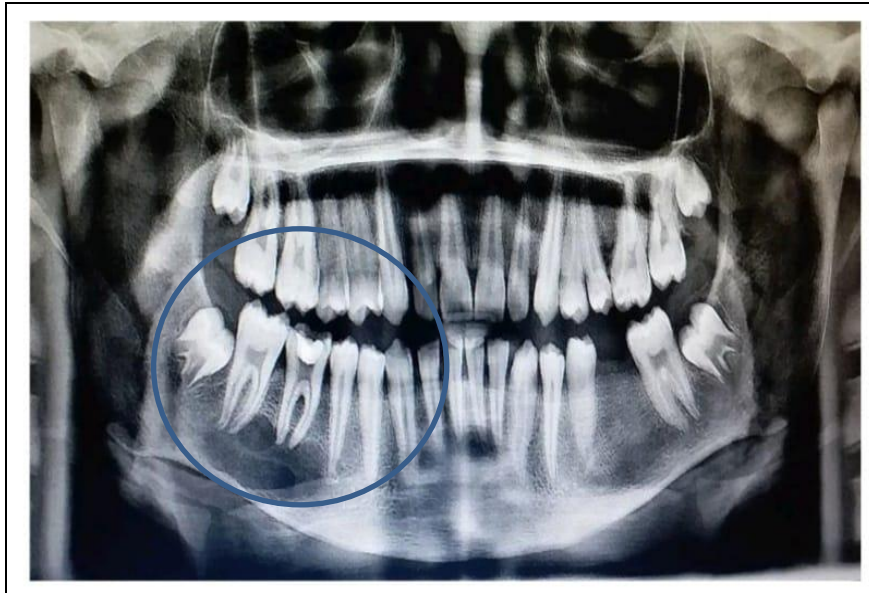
Orthopantomograph showing radiolucency in the right mandibular body region.
